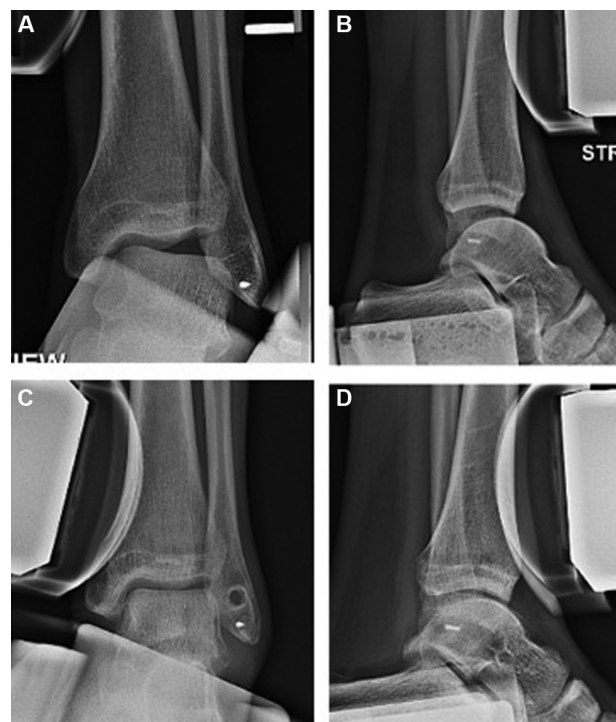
Example of pre- and postoperative stress radiographs of a patient who underwent lateral ligament reconstruction after a failed primary ligament repair procedure. Preoperative radiographs demonstrate increased talar tilt and anterior drawer, which are substantially improved at 9 months postoperatively. (A) Preoperative anteroposterior stress radiograph. (B) Preoperative lateral stress radiograph. (C) Postoperative anteroposterior stress radiograph. (D) Postoperative lateral stress radiograph.
